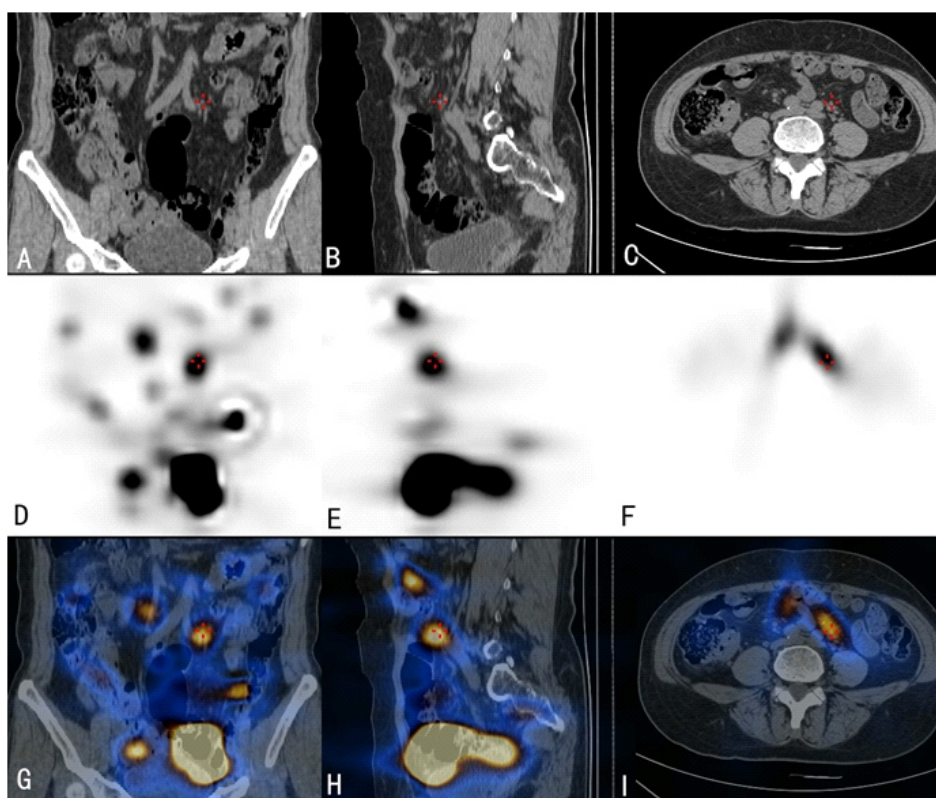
Tomographic images of ^{131}I WBS. The red cross arrows label the implantation metastasis in mesentery, seen as a small nodule in mesentery in CT (A, B and C), abnormal ^{131}I concentration in single photon emission computed tomography (SPECT) images (D, E and F) and corresponding SPECT/CT fusion images (G, H and I).
